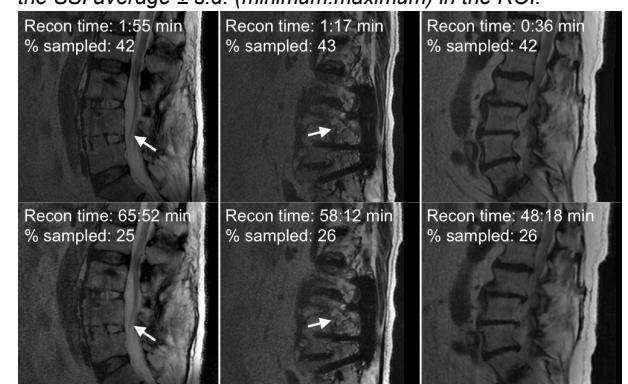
Three T2-weighted MSI cases. Top: original; bottom: retrospective CS. The percent sampled in the fully-sampled half-Fourier is under 50% due to cut k-space corners. The arrows point to nerve roots that are well depicted in all images.
